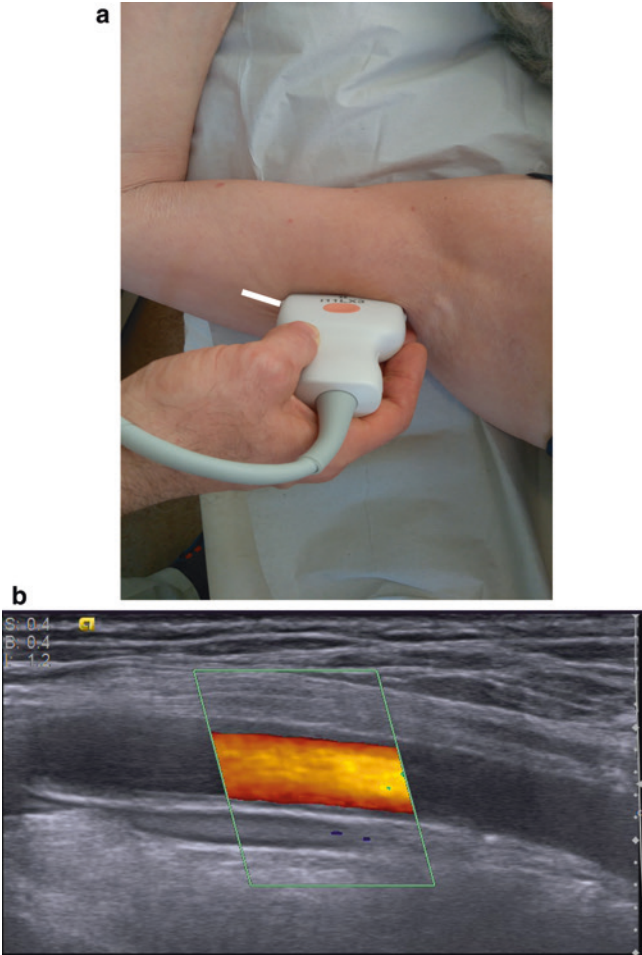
Examination of the distal axillary artery, axillary approach: a recommended transducer position, b ultrasonographic view of the distal axillary and brachial artery (including the deep brachial artery-black arrow)
